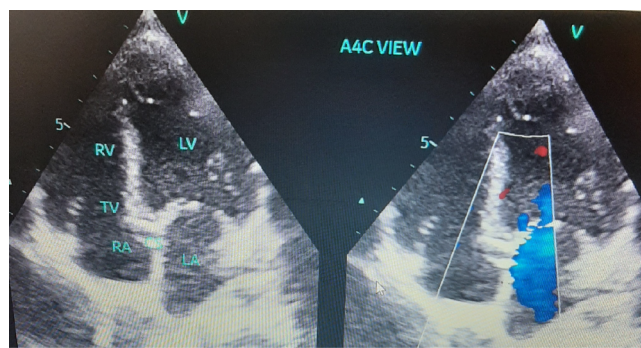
Modified apical four-chamber view showing coronary sinus free of vegetation (echo done after resolution of Coronary Sinus Infective Endocarditis, CSIE). RV right ventricle; LV, left ventricle; LA, right atrium; VEG, vegetation; MV, mitral valve; TR, tricuspid valve.
